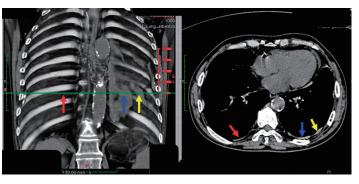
Image of pleural plaque and intercostal veins using 3D CT (left) Image taken using conventional CT image (right)
